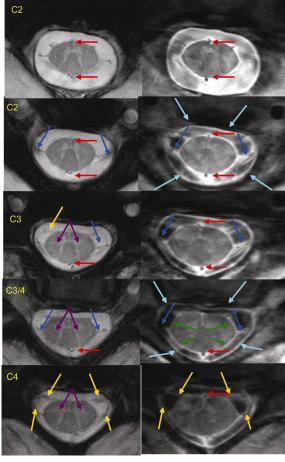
C-spine MRI at 7 T (4-ch array) with T2 FLASH and TSE sequences. Labeled structures: dorsal/ventral nerve roots (yellow), gray matter anterior horn (purple), denticulate ligament (blue), dorsal/ventral blood vessels (red), dura mater (cyan), arachnoid (green).
